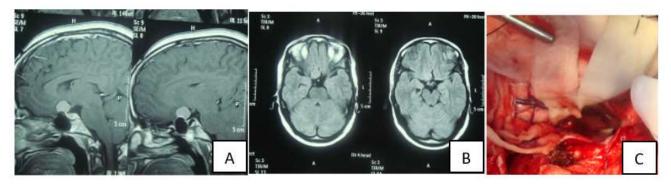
Image (A)and (B) are the preoperative MRI of case no(5) showing the tumor, Image (C) is an operative image showing tumor resction cavity
